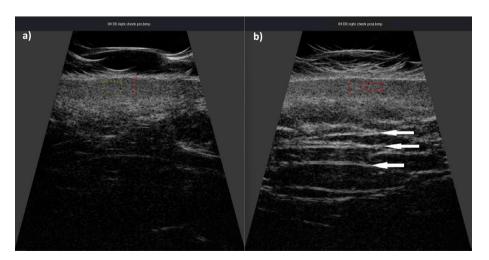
Participant 1. Ultrasound imaging with DermaMed device, 48 MHz probe: a) prior to injection, b) immediately after injection. The images suggest that in certain areas, the injected product may have partially infiltrated the subcutaneous tissue. Source: Author's own archive
